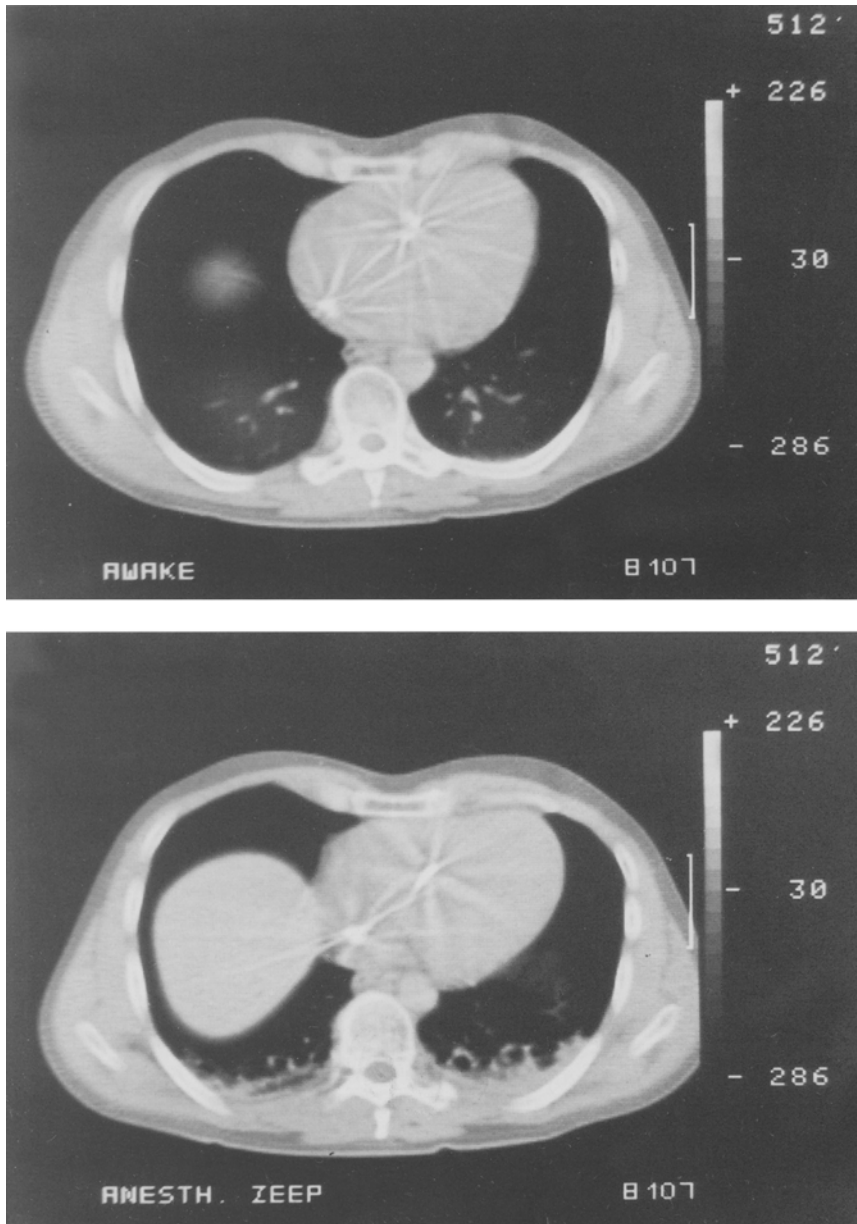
Computed tomographic scans of a patient's lungs (at a level above the right hemidiaphragm) while awake (*top panel*) and during general anesthesia with mechanical ventilation (*bottom panel*). Note the appearance of atelectasis in the dependent part of the lungs after induction of anesthesia
